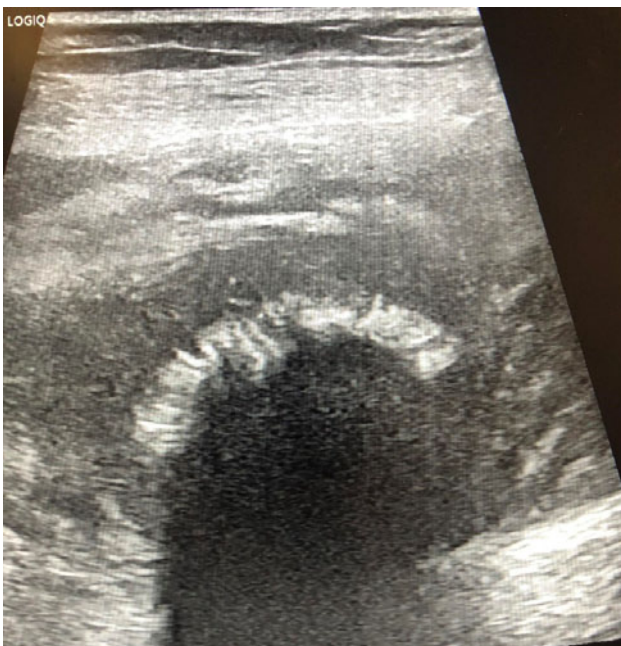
ultrasound of the femur, transverse projection, interface of the middle and lower 1/3 of the femur, spicular periosteal reaction
